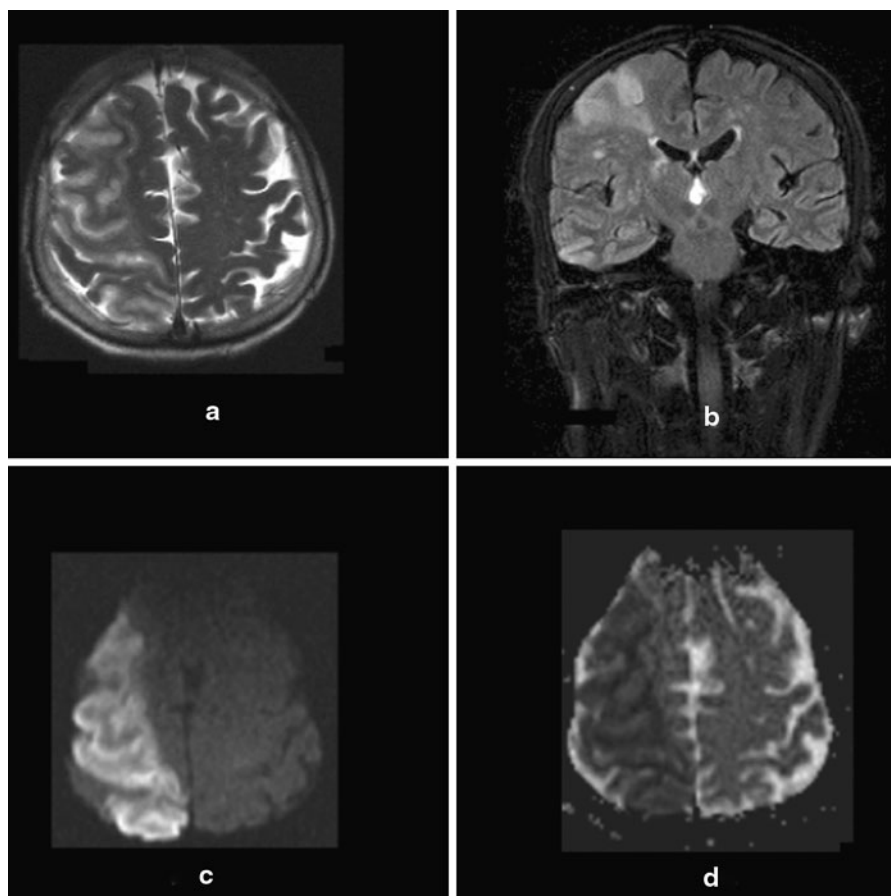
Follow-up MRI examination shows marked progression of the cerebral watershed infarction (a T2-weighted, b FLAIR, c b1000, and d ADC map)
